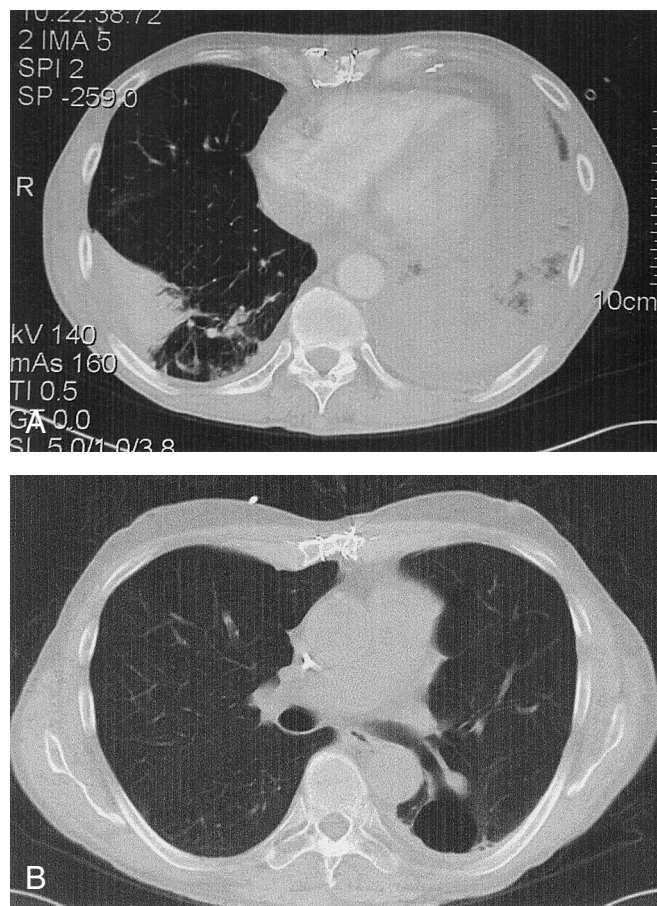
A, Chest CT following induction chemotherapy for AML, showing extensive left-lower-lobe consolidation and infarct and a right-lower-lobe wedge-shaped infarct with an adjacent loculated effusion due to biopsy-proven aspergillus infection. B, Chest CT 8 months later showing evolution of the left-lower-lobe infarct into a 3.5 \times 3.5 cm² cavitary structure in communication with the left-lower-lobe bronchus. No active pulmonary disease is seen.
